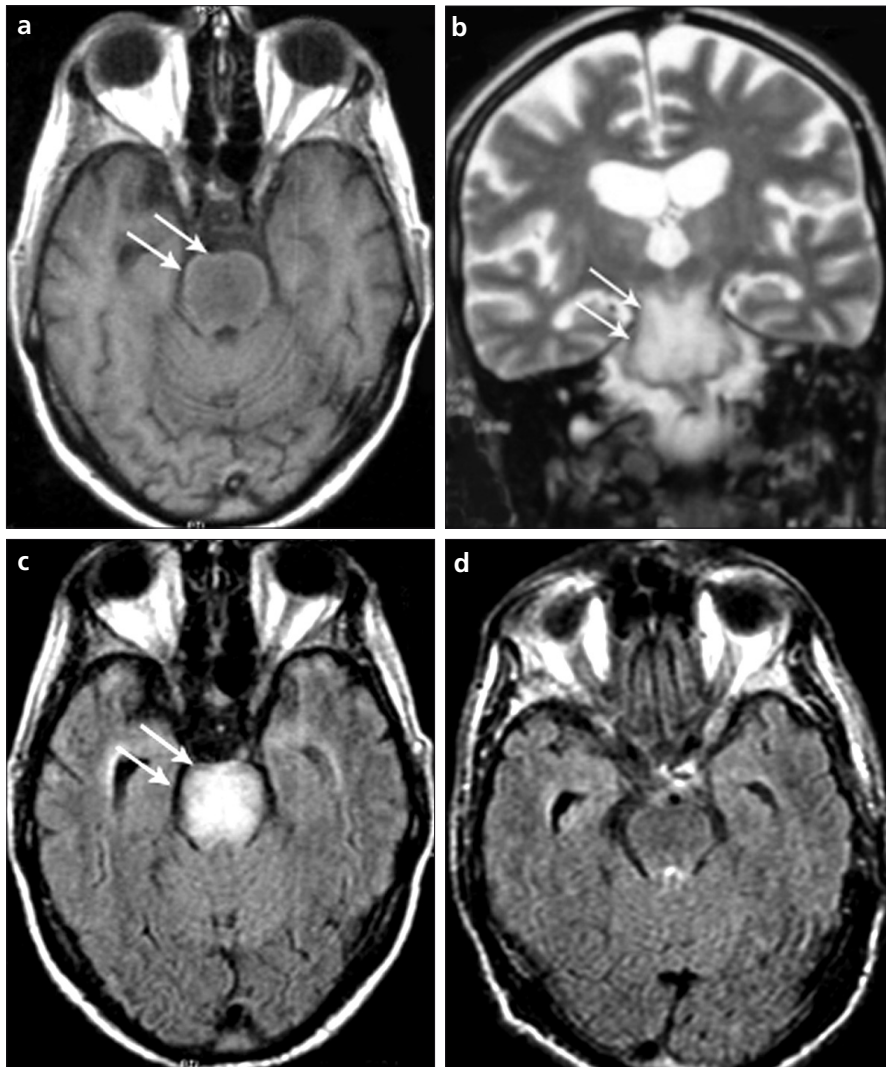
a–d. Axial T1-weighted (a), coronal T2-weighted (b), and axial FLAIR (c) MR images show edema in the central pons (*arrows*) and preservation of the tegmentum and ventrolateral aspects of the pons. Axial FLAIR MR image (d) repeated six weeks later shows that the lesion has completely resolved.
